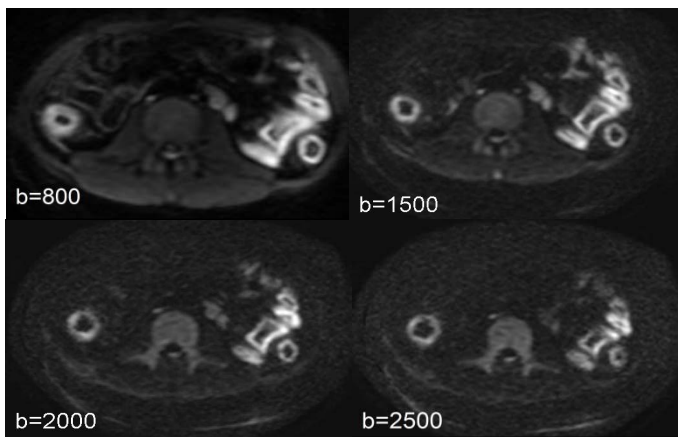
The DWI images were obtained in a 28-year-old man. There were high signal intensity in ascending colon, descending colon and jejunum on all four DWI sequences and retroperitoneal lymph nodes enlarged and the signal intensity were also increased. The intestinal structure was clear when b value 800 was chosen but when b value 2000 or 2500 was chosen, the intestinal structure adjacent to lesions was quite vague.
